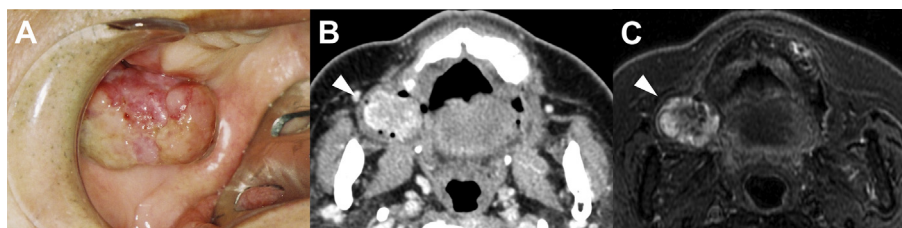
Clinical photograph and imaging examinations of the nonpregnant patient suspected of having epulis. (A) Intraoral photograph. (B) Computed tomography showed the lesion (white arrow). (C) T2-weighted magnetic resonance imaging showed high signal intensity in the lesion area (white arrow).
